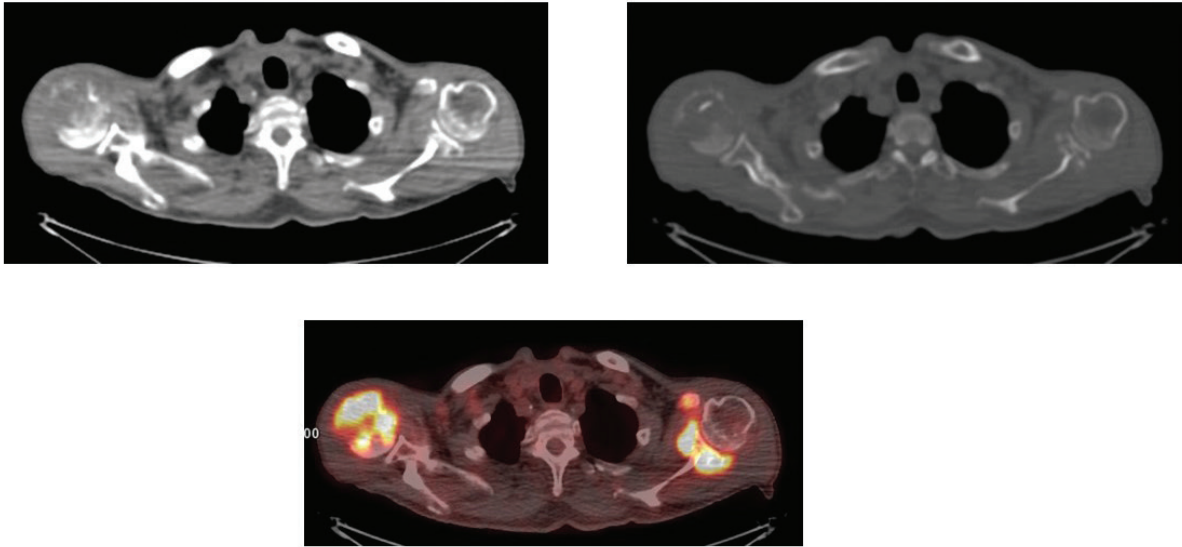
Right femoral bone head osteolysis with soft tissue mass and high-grade uptake (SUVmax=16,8). Left scapula acromion, glenoid fossa osteolysis with soft tissue mass and high-grade uptake (SUVmax=18,5). Pathologic enlarged axillary lymph nodes (diameter 1,3cm) with uptake (SUVmax=6,5).
